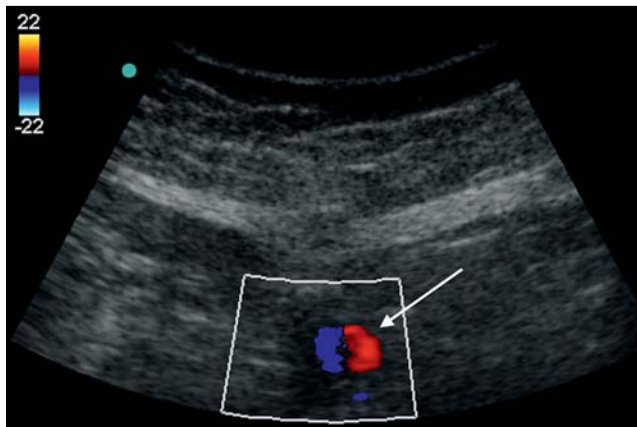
Doppler ultrasound demonstrating the classic “Ying Yang” or biphasic appearance (arrow) of a pseudoaneurysm.
